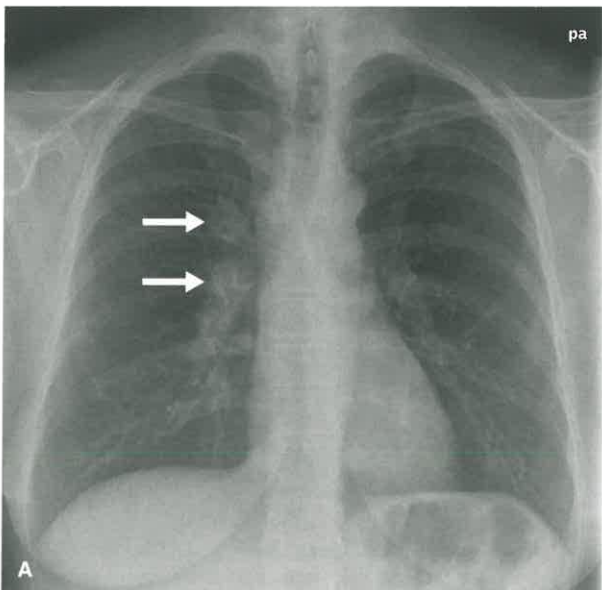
Bronchogenic Carcinoma as Enlarged Hilar Lymph Nodes. A: Frontal chest radiograph in a 49-year-old woman with chest tightness shows an enlarged right hilum (*arrows*). B: Coronal contrast-enhanced CT through the right hilum shows an enlarged right hilar lymph nodes (*arrows*). Bronchoscopic biopsy revealed non-small cell carcinoma.
